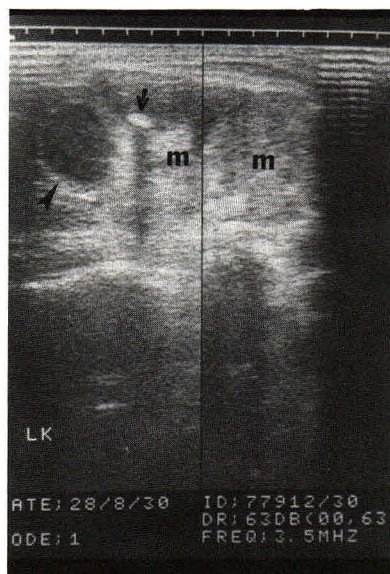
A longitudinal sonogram of the left kidney shows hyperechoic masses (m) at the lower pole with hydronephrosis (arrow head) and stone (arrow).
